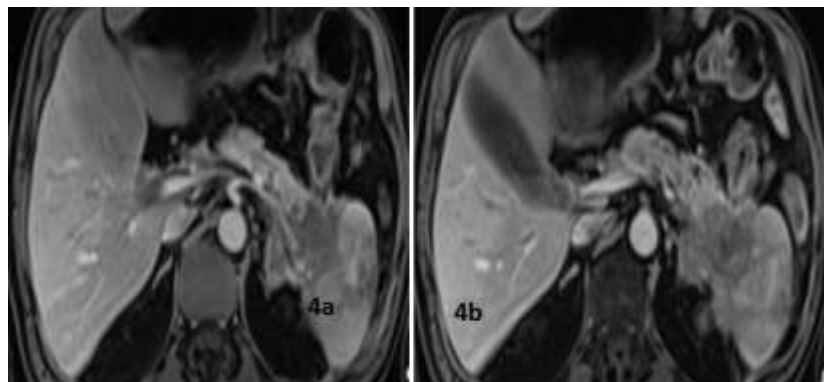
CE MRI of upper abdomen: Axial plane: Pancreas tail neoplasm with infiltration of spleen and liver metastase.
